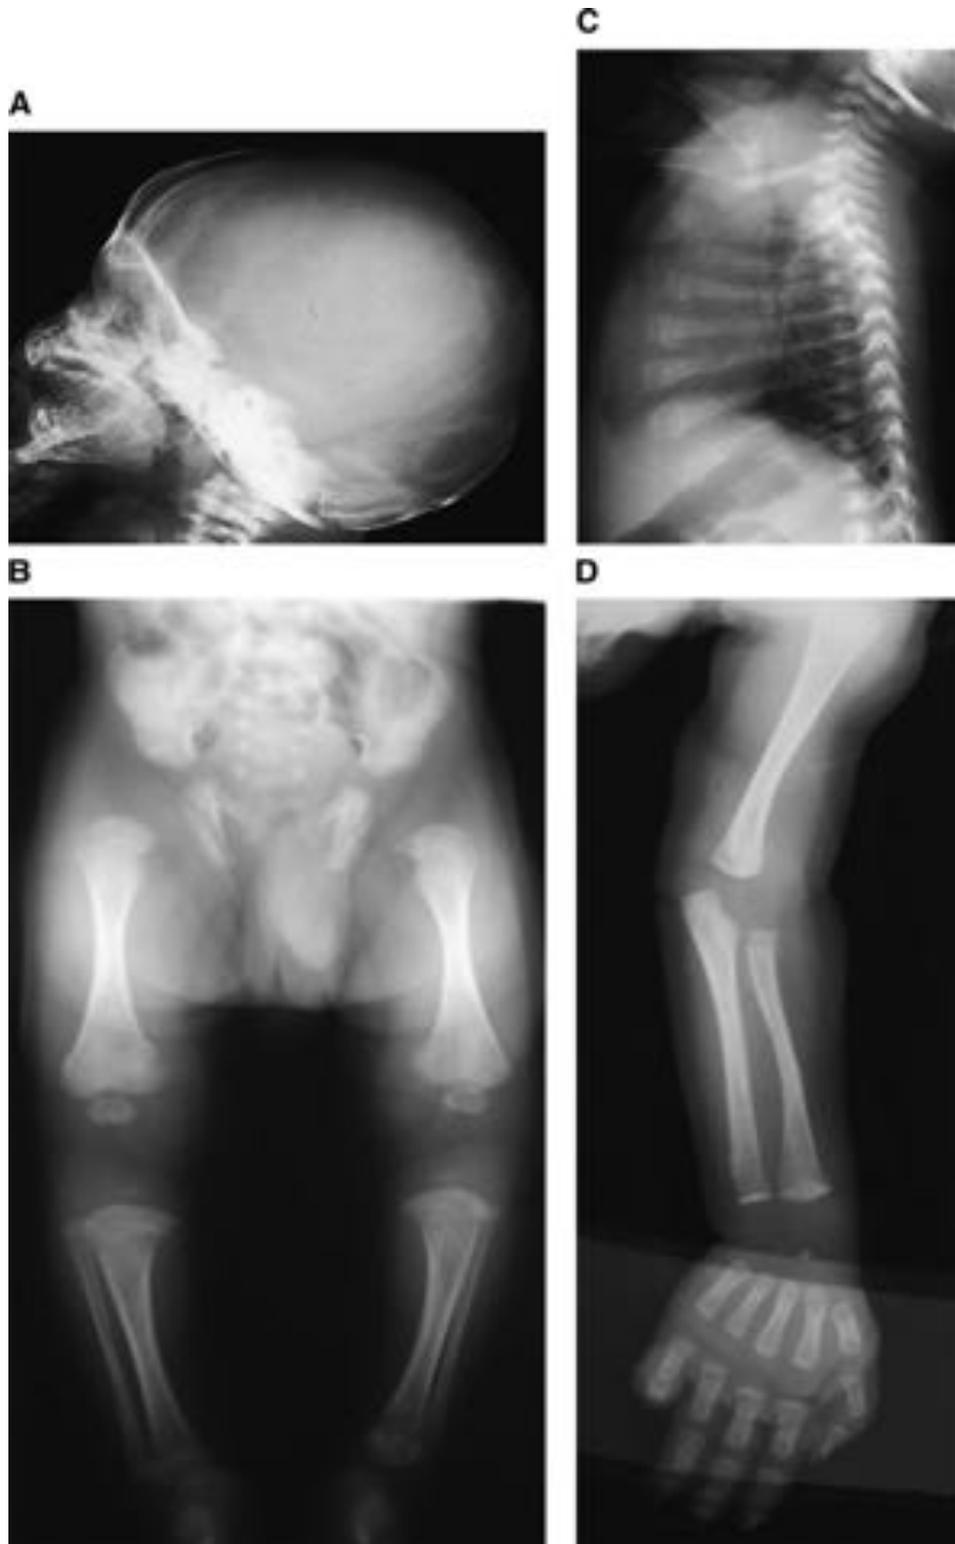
Radiograph examination of the propositus at birth and 2 months old. A: Skull radiograph showing wide sutures and wormian bones. B: Lower limb radiograph showing mild bowing of the tibiae, enlarged and round metaphyses, normal cortical thickness. C: Spinal radiograph with multiple vertebral collapses in the lumbar spine with osteoporosis. D: Upper limb radiograph with distal end of the radius fractured.
